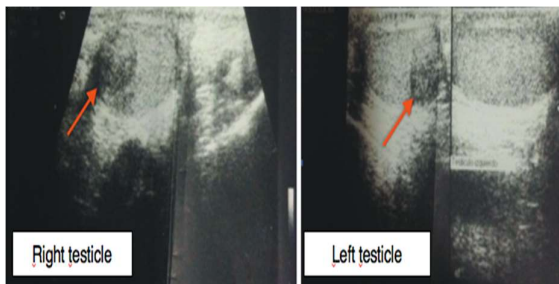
Testicular ultrasonography: bilateral intraparenchymatous hypoechoic lesion.
